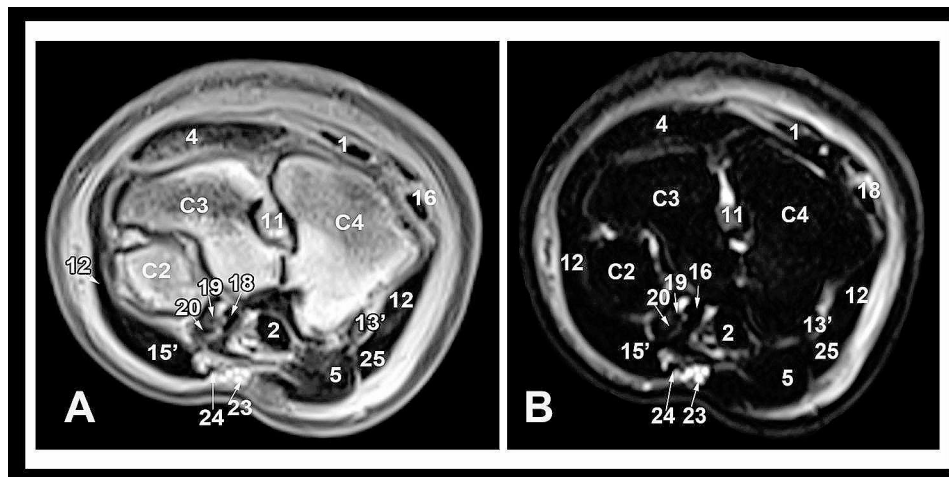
Transverse T1-weighted (A) and STIR (B) high-field MRI images at the level of the distal row of carpal bones. Medial is to the left. C2, 2nd carpal bone; C3, 3rd carpal bone; C4, 4th carpal bone; 1, common digital extensor tendon; 2, deep digital flexor tendon; 4, radial carpal extensor tendon; 5, superficial digital flexor tendon; 11, short inter-carpal ligament; 12, long lateral collateral carpal ligament; 13', short lateral collateral carpal ligament; 14, long medial collateral carpal ligament; 15', short medial collateral carpal ligament; 16, lateral digital extensor tendon; 18, radial carpal flexor tendon; 19, median artery; 20, median vein; 23, radial artery; 24, radial vein; 25, accessoriometacarpal ligament
